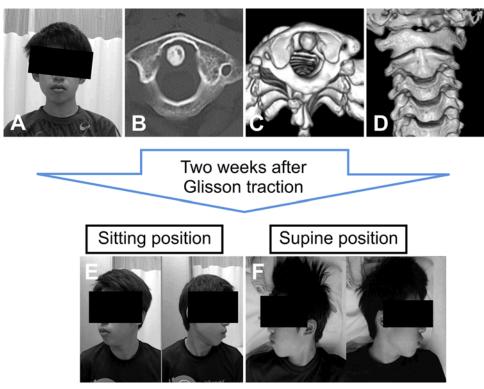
Reference case: a 12-year-old boy presenting with inflammation. A: Residual slight torticollis. B: Height of the atlas on CT. C: 3D CT, Fielding type I. D: 3D CT showing no engagement of the joint surface or formation of osteophytes. E: In the sitting position, ROM restriction remained 2 weeks after Glisson traction. F: In the supine position, ROM restriction disappeared. Figure is available in color online only.
